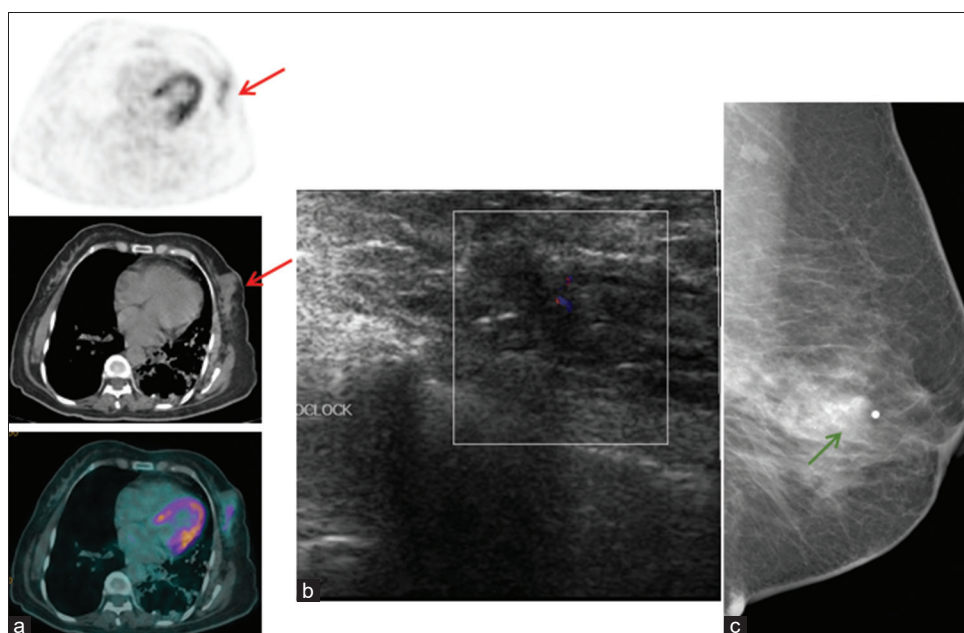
A 58-year-old female with a history of rectal carcinoma; positron emission tomography/computed tomography revealing mild hypermetabolic left breast lesion (red arrows, a), ultrasound (b) revealing a hypoechoic mass infiltrating posteriorly to the chest wall that correspond to a lower outer quadrant mass seen by mammogram (c) extending to retro-areolar region with amorphous calcification (green arrow). Tru-cut biopsy revealing papillary sclerosing duct papilloma; lumpectomy revealing 1-cm invasive ductal carcinoma with extensive intraductal carcinoma solid, cribriform, and micropapillary pattern
